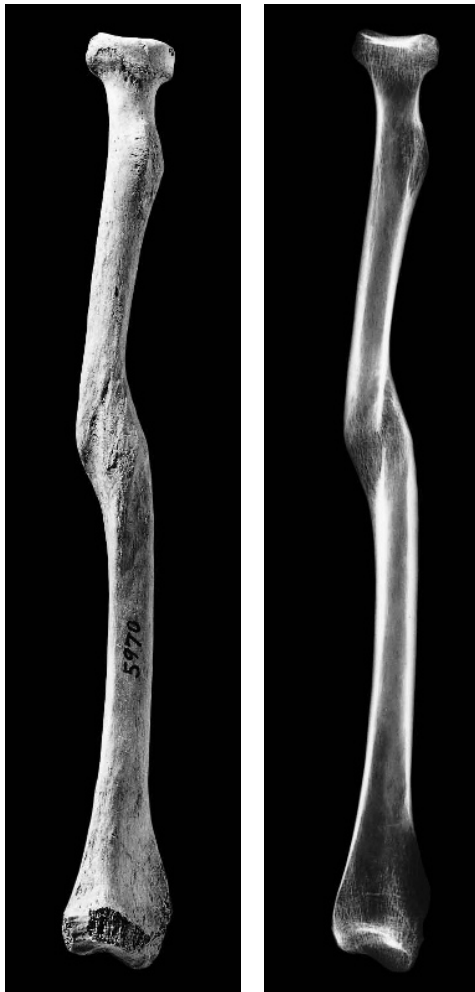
Healed fracture. (*Left*) This left radius has a healed midshaft fracture. The radiograph shows that the fracture offset is about equal to the width of the bone. The proximal part of the bone is offset posteriorly. Prehistoric, California. One-half natural size.
